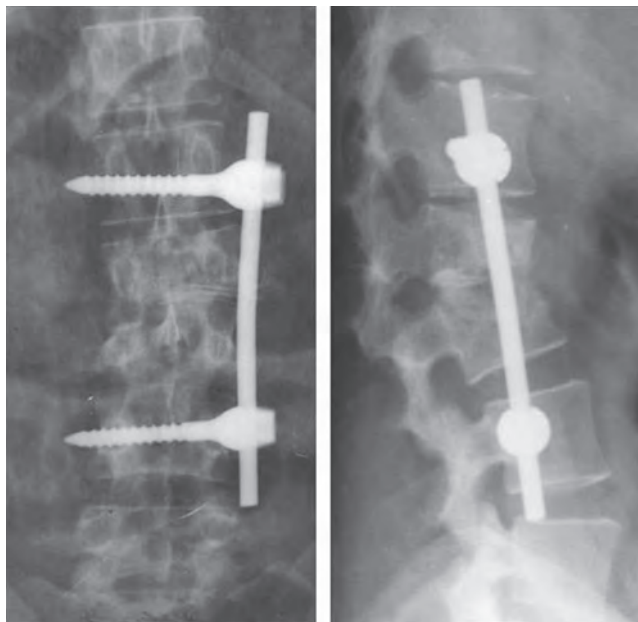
Post-operative X-rays showing spinal fixation done by the retroperitoneal approach
